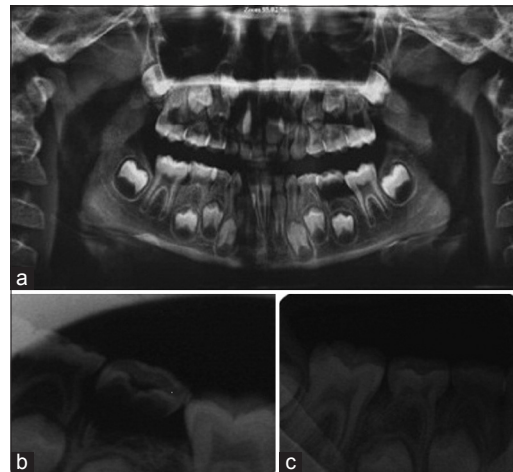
(a) Orthopantomogram X-ray showed severe inflammatory root resorption of left second mandibular molar and mild replacement of root resorption of right mandibular molar. (b and c) posteroanterior X-rays of affected areas
